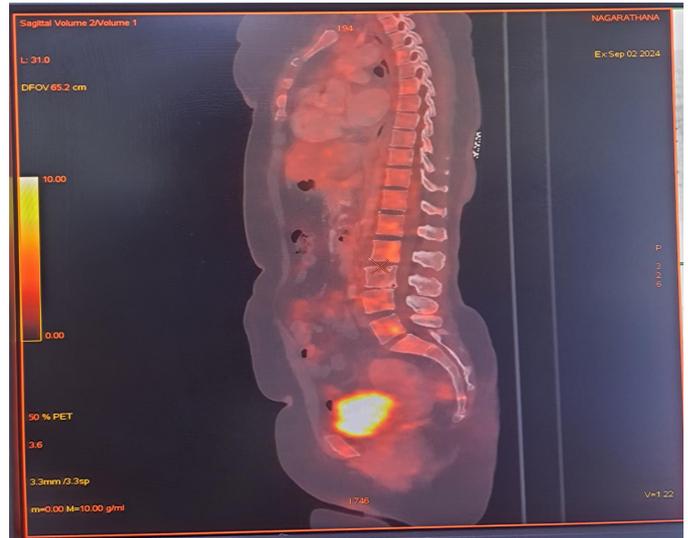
PET-CT image showing multiple FDG avid skeletal lesions involving cervico-dorso-lumbar spine
